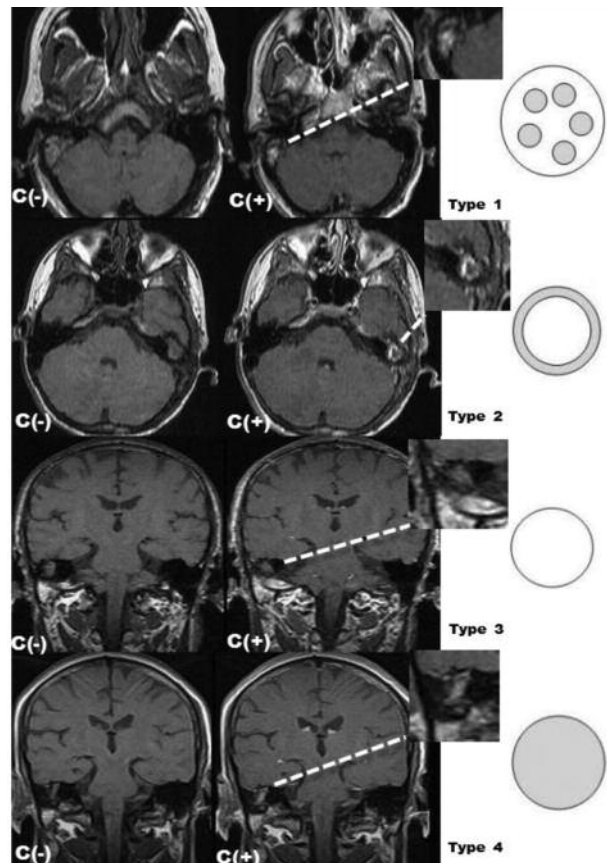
Dynamic contrast-enhanced Magnetic resonance imaging (DCE-MRI) were classified Type 1: Progressive heterogeneous enhancement; Type 2: More pronounced enhancement towards the periphery of the lesion without central enhancement (rim enhancement) in the delayed phase; Type 3: Non-enhancement; Type 4: Progressive homogeneous enhancement
